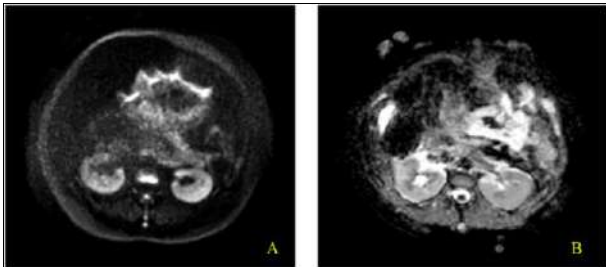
DWI (A) and ADC (B) axial images show no evident diffusion restriction within the right perinephric collection
